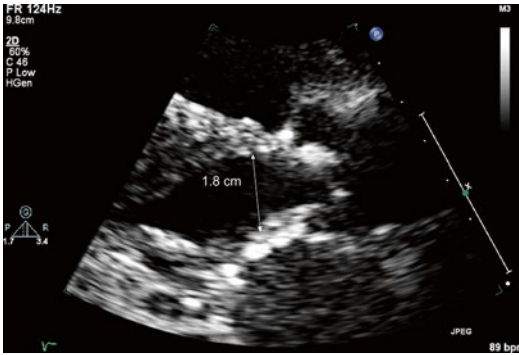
Zoomed parasternal long axis view of the left ventricular outflow tract (LVOT) demonstrating method of measurement of the LVOT diameter, which in turn is used to calculate LVOT area used in the continuity equation
